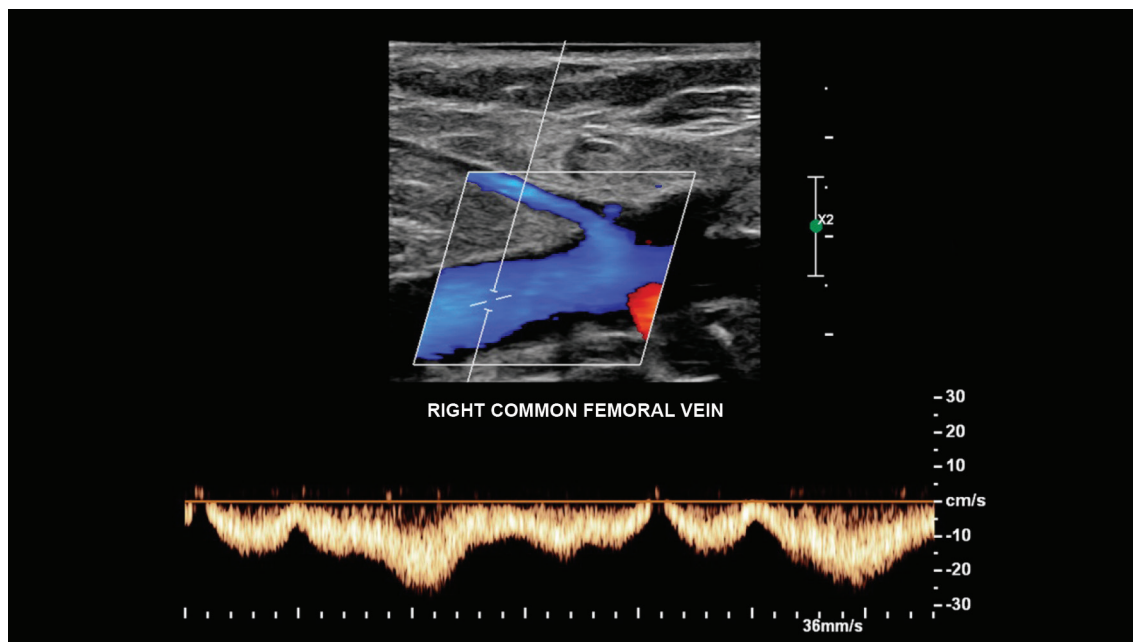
Pulsed Doppler of the common femoral vein showing normal phasic flow in response to breathing movements, consistent with the absence of occlusive thrombosis.
